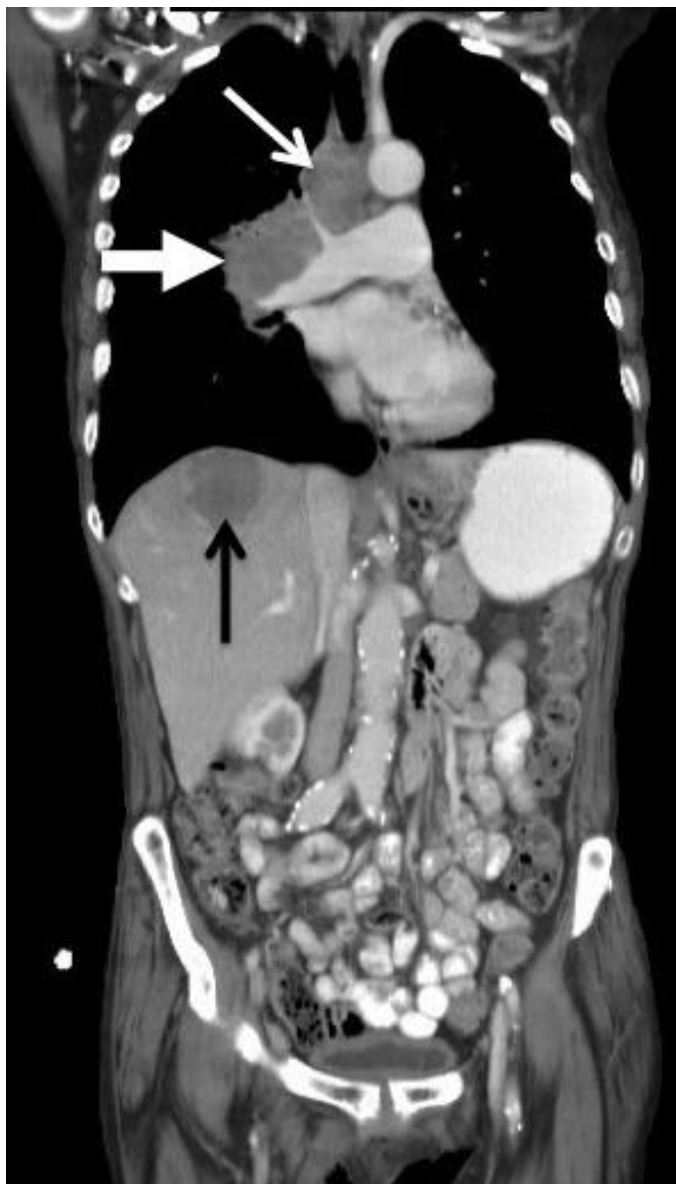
(left): 58 year old female with a 2 year history of a hyperpigmented rash who was found to have Bazex syndrome presented for CT after an abnormal chest radiograph. Contrast enhanced coronal reformatted CT images of the chest demonstrates the presence of large right perihilar soft tissue mass (thick white arrow), associated right paratracheal adenopathy (thin white arrow) and a focal right hepatic lobe metastatic lesion (black arrow). (protocol: 250 mAs, 120 kvp, 5mm slice thickness, venous phase, 100 cc isoview-300)
